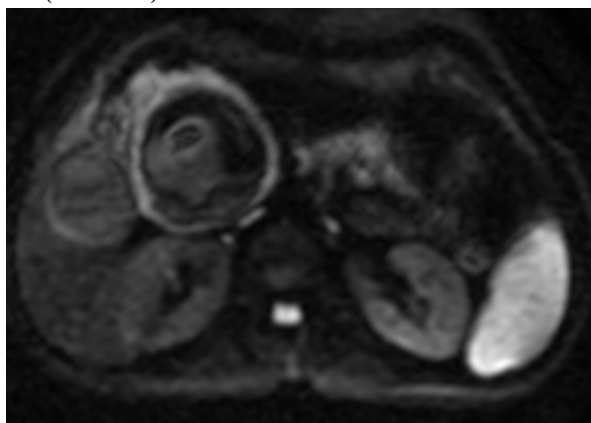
Axial diffusion weighted MRI image showing mild peripheral diffusion restriction in the cystic lesion.
